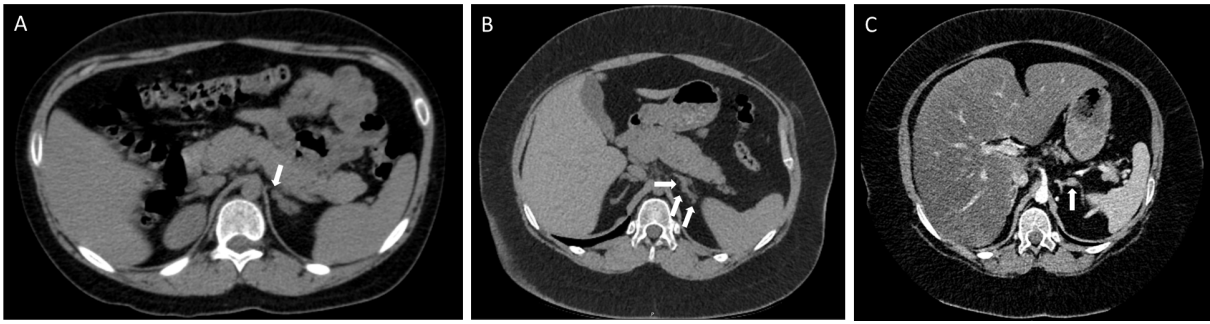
Adrenal CT images showing numerous adrenal nodules of varying sizes: (A) Case 1, (B) Case 2, and (C) Case 3
